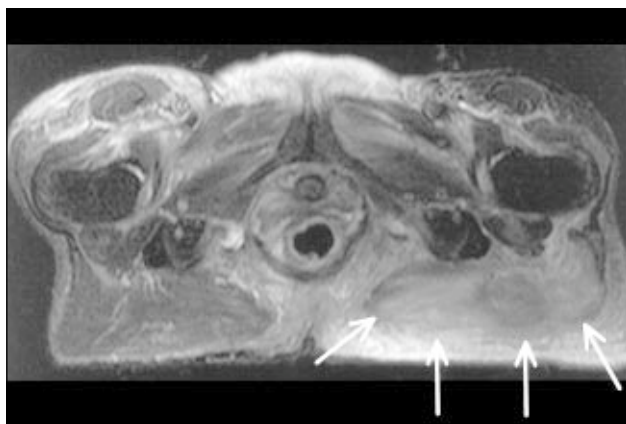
T2-weighted fat suppressed axial magnetic resonance imaging of the pelvis at the level of the pubic symphysis
